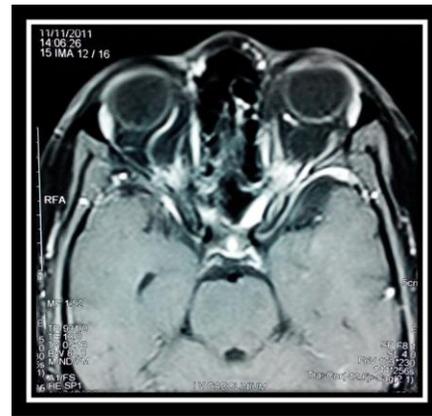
MRI showing Bilateral cavernous sinus (CS) infiltration and orbital apex syndrome (OAS) with left optic neuritis (ON)
